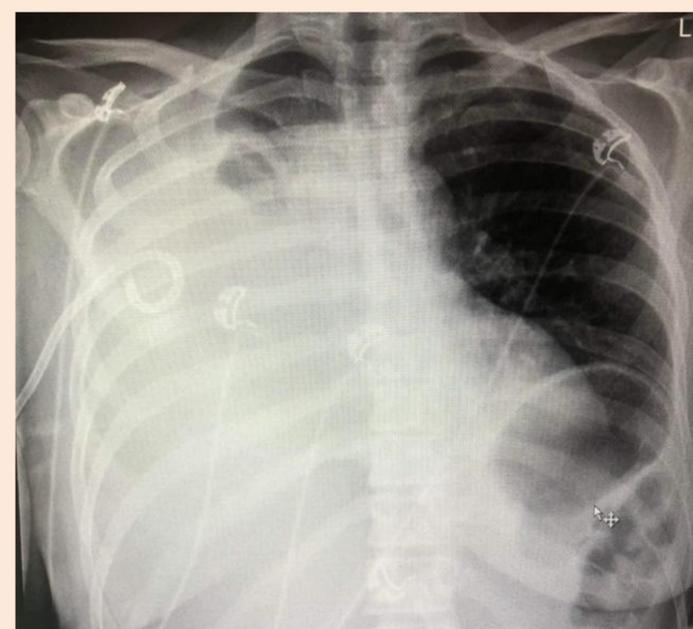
Chest x-ray demonstrating right-sided massive pleural effusion with chest drain in situ
